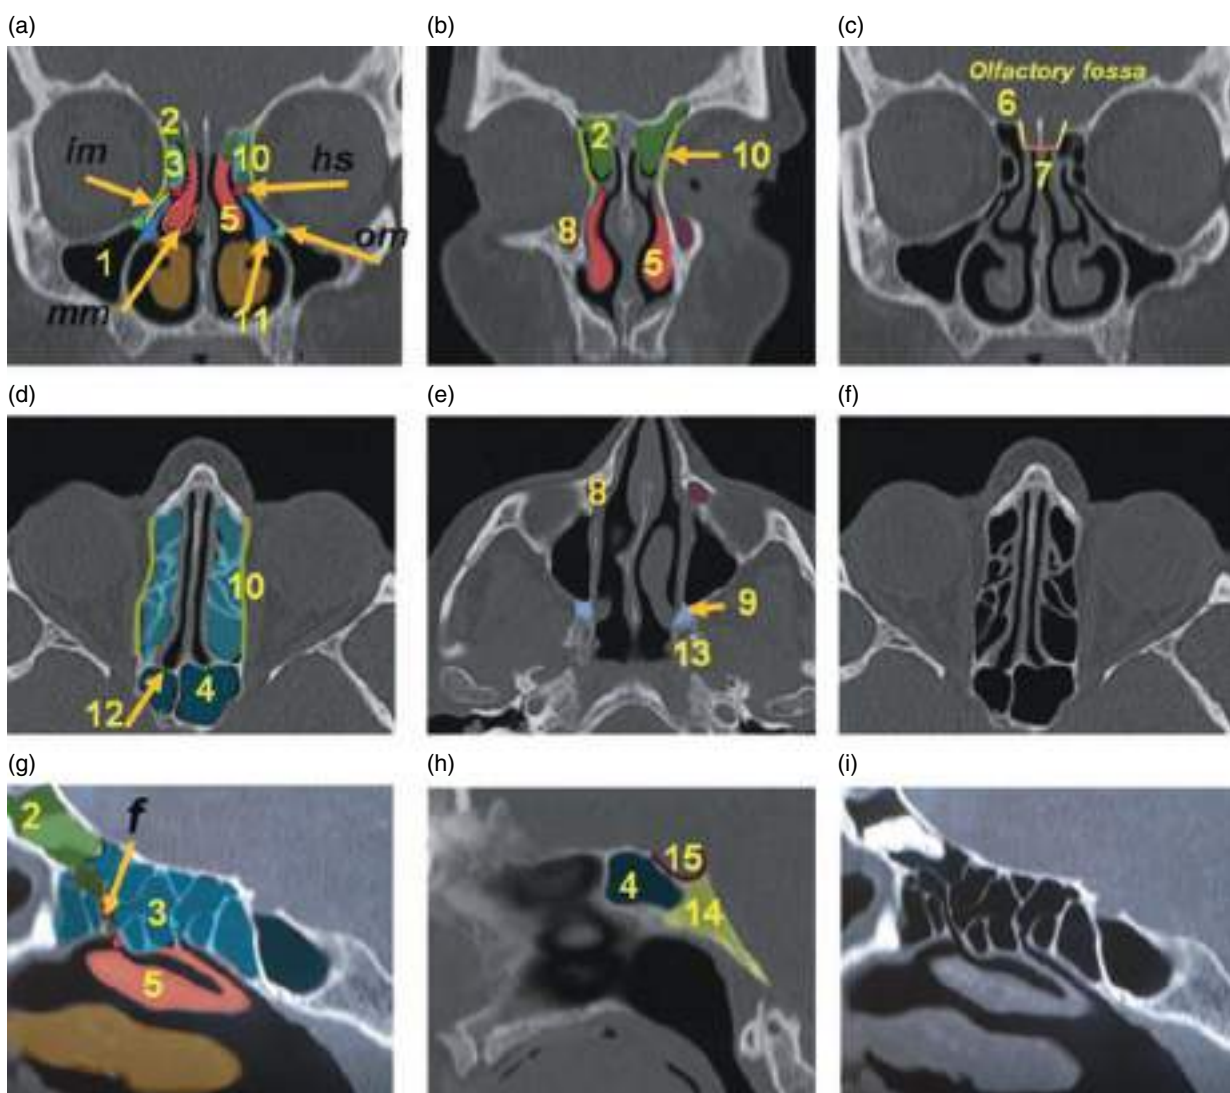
Paranasal sinuses. (a–c) Coronal noncontrast MPR CT images (bone window). (d–f) Axial noncontrast CT images (bone window). (g–i) Sagittal noncontrast MPR CT images (bone window). 1, maxillary sinus; 2, frontal sinus; 3, ethmoidal air cells; 4, sphenoid sinus; 5, middle concha; 11, uncinete process; MO, maxillary ostium; MM, middle meatus; HS, hiatus semilunaris. Spenoethmoidal recess: 12, olfactory fossa; 6, lateral lamella; 7, cribriform plate. Frontal recess: FR (red dots), drainage pathway of the frontal sinus into the middle meatus; 8, nasolacrimal duct; 9, pterygopalatine fossa; 10, lamina papyracea; 13, pterygoid process; 14, clivus; 15, sella turcica.
